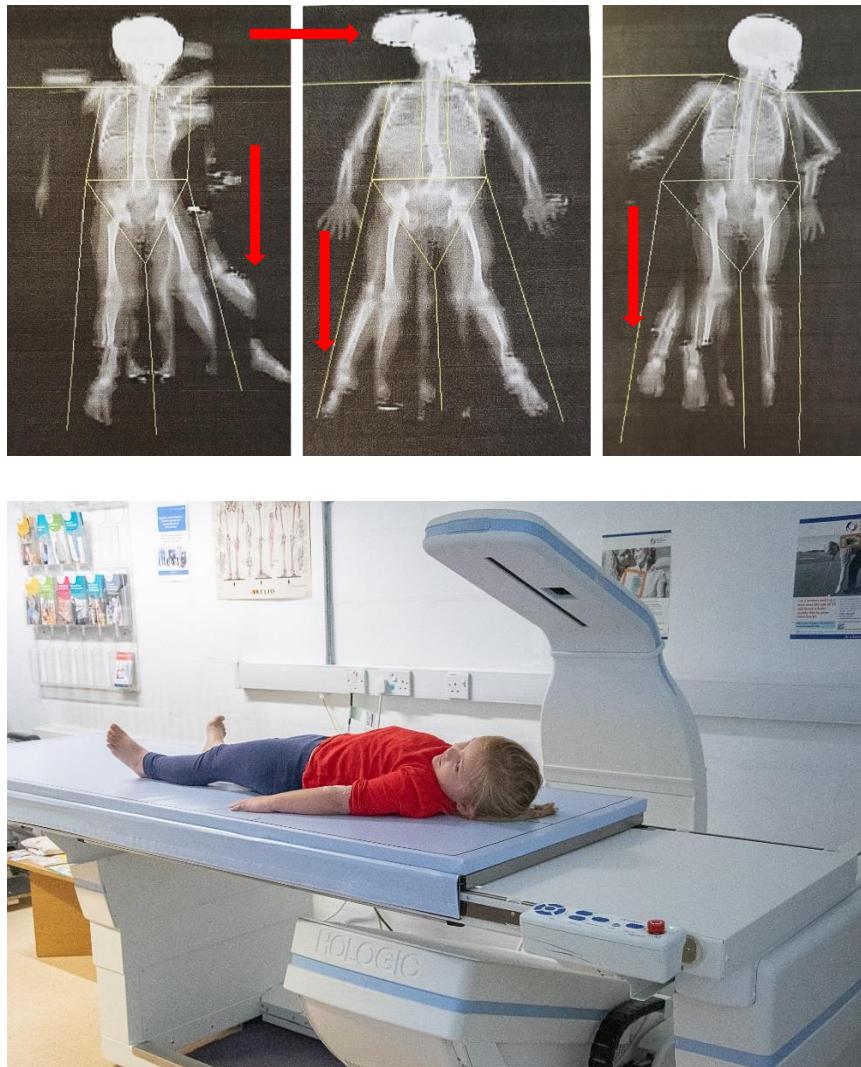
Examples of movement artefact (multiple limb images, skull images, indicated with arrows) in DXA scans collected at age 4 years in the MAVIDOS study, and a child undergoing DXA using the Hologic Horizon Dual Energy X-ray Absorptiometer
